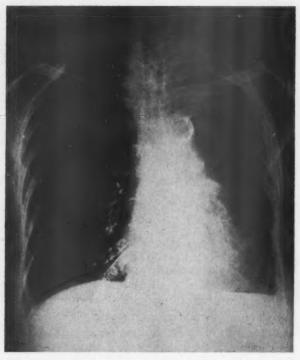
Clinical x-ray film showing severe calcification of arch of aorta (circular shadow).
